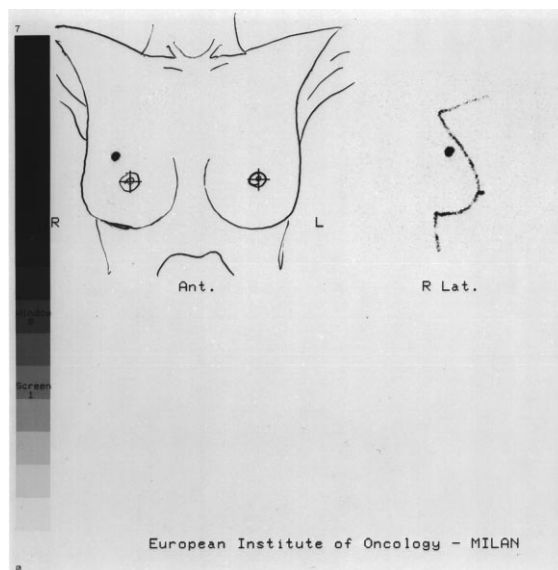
Anterior and lateral projections of the location of the lesion on scintigraphy.
